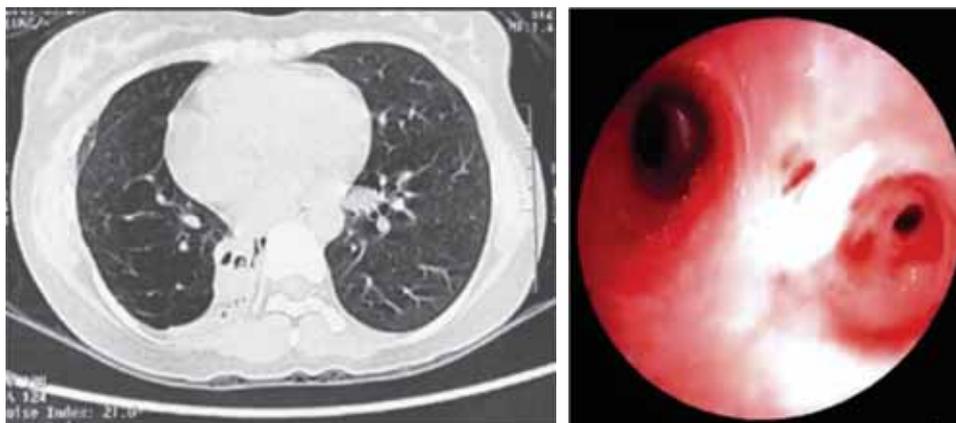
(a) HRCT chest (one year later) showing loss of volume in right hemithorax, atelectatic right lower lobe with stenotic airways (b) bronchoscopic image showing patent right middle lobe (left) stenotic pus filled right lower lobe segments (right).
